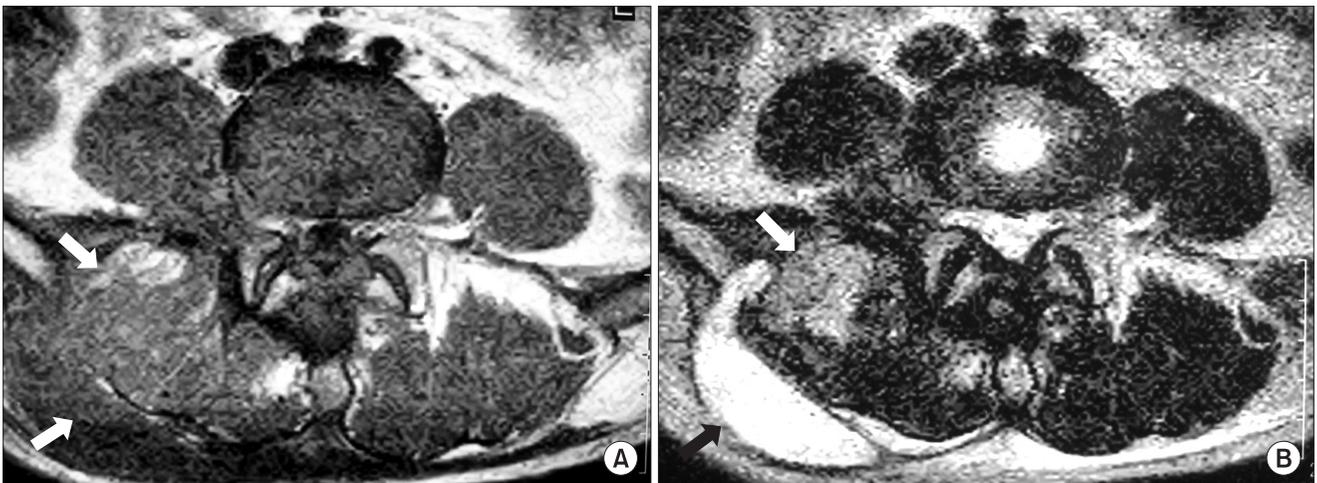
(A) Axial T1-weighted magnetic resonance imaging (MRI) reveals an intermediate signal intensity lesion (white arrow). (B) Axial T2-weighted MRI reveals high signal intensity in the space-occupying lesion (black arrow), which was located behind the right paraspinal muscle, and intermediate signal intensity in the muscle (white arrow).
